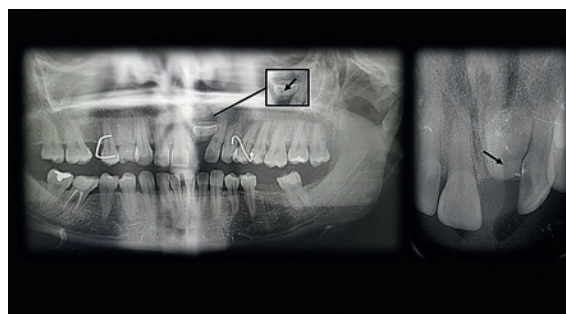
Radiographic examination. The characteristic bull’s eye image is observed on the OPG radiograph (Left) and the periapical radiograph (right)
